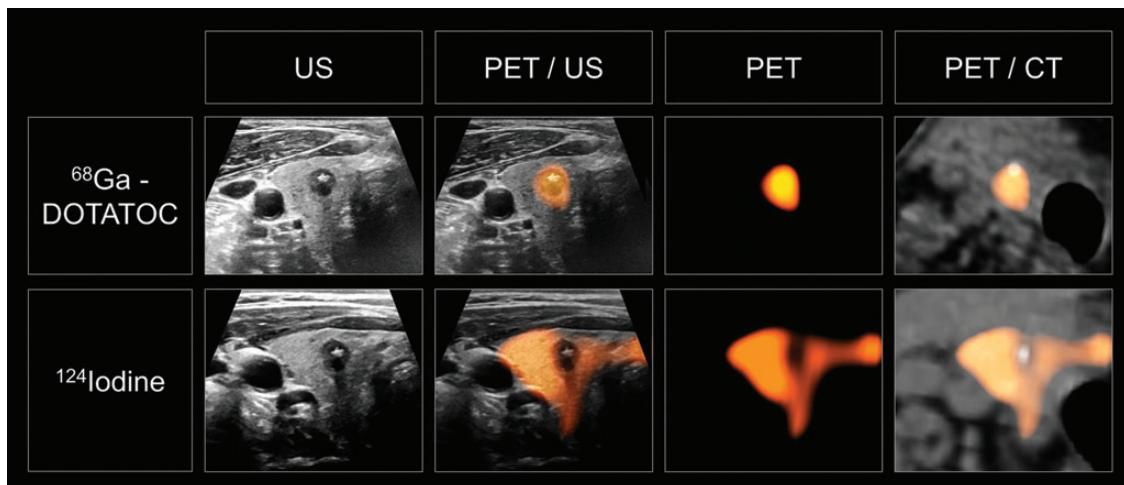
Image of the Month*Diagnosis of Small Medullary Thyroid Carcinoma via PET/Ultrasound (US) FusionFigure 1.Figure 2.
